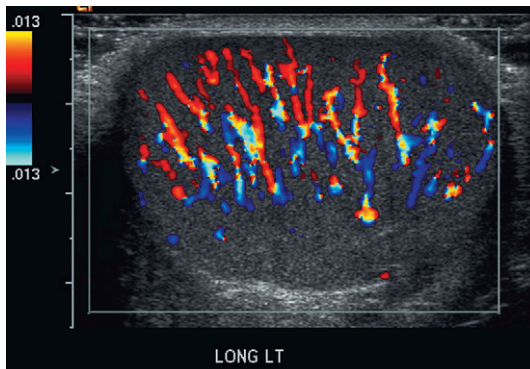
Longitudinal colour Doppler image of a testicle. With very sensitive Doppler settings, the network of centripetal arteries is seen fanning across this normal testicle.
